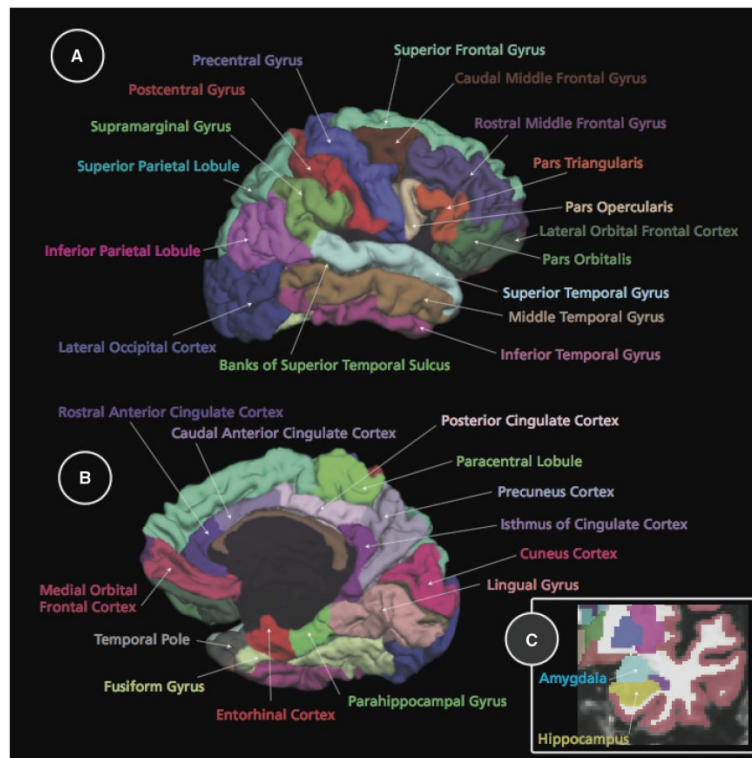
3D representation of all 34 Regions of Interest (ROI) provided by the cortical parcellation from FreeSurfer, (A) lateral view, (B) medial view, (C) the two non-neocortical regions visible in the coronal view of a T_1 -weighted MRI, got from [13]
